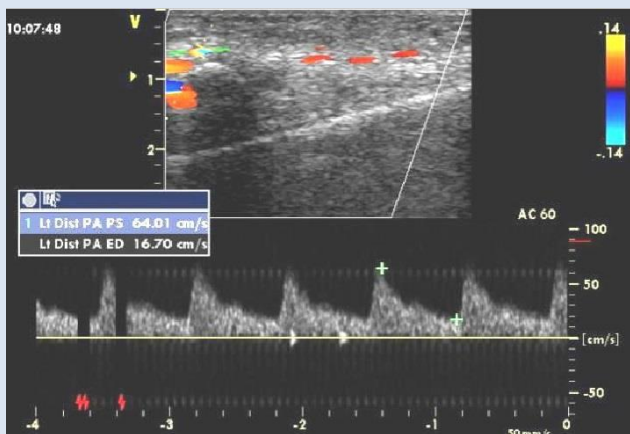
Biphasic waveform pulse wave doppler of left palmar artery. (PS Velocity 64 cm/s)
